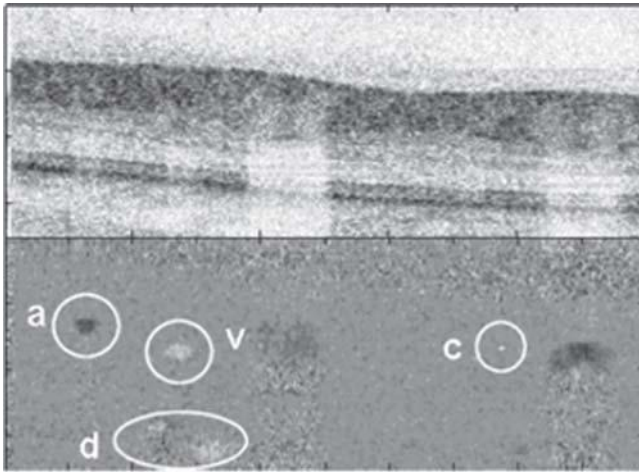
FDOCT reflectance image of retinal tissue (top) and corresponding Doppler phase map (bottom). The map shows flow in a large artery–vein pair as well as in a small capillary and choroidal vessels. (From [288], with permission.)
